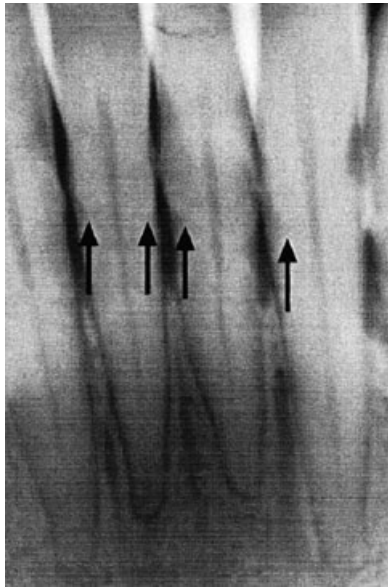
Subgingival calculus may be visible (arrows) on radiographs if abundant deposits are present.
